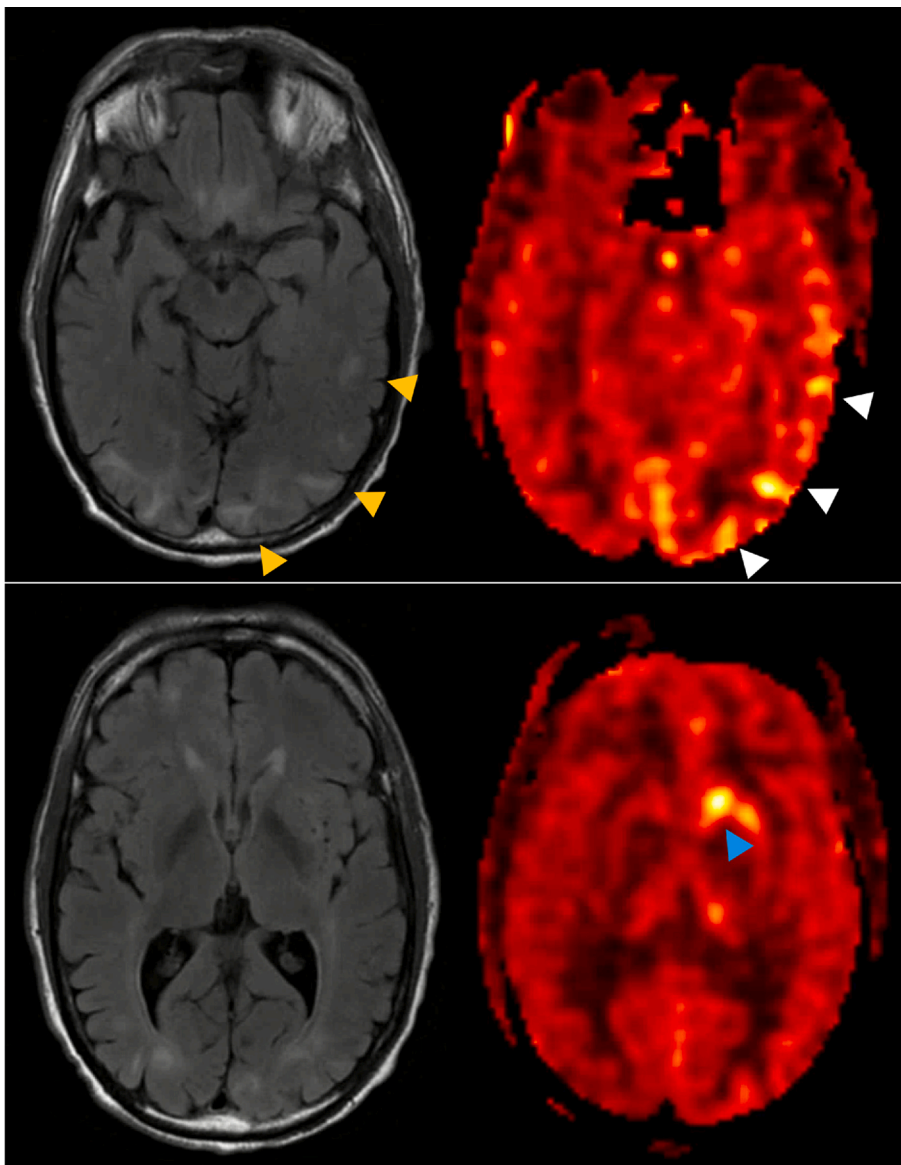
A representative example of both matched and unmatched ASL and FLAIR abnormality. Axial T2 FLAIR (left) and ASL color (right) perfusion maps in a 59-year-old male with HTN-induced PRES. Hyperperfusion (white arrowheads) is noted corresponding to the regions of FLAIR hyperintensity (orange arrowheads). Hyperperfusion without any corresponding FLAIR hyperintensity is seen in the left basal ganglia (blue arrowhead). (For interpretation of the references to color in this figure legend, the reader is referred to the web version of this article.)
